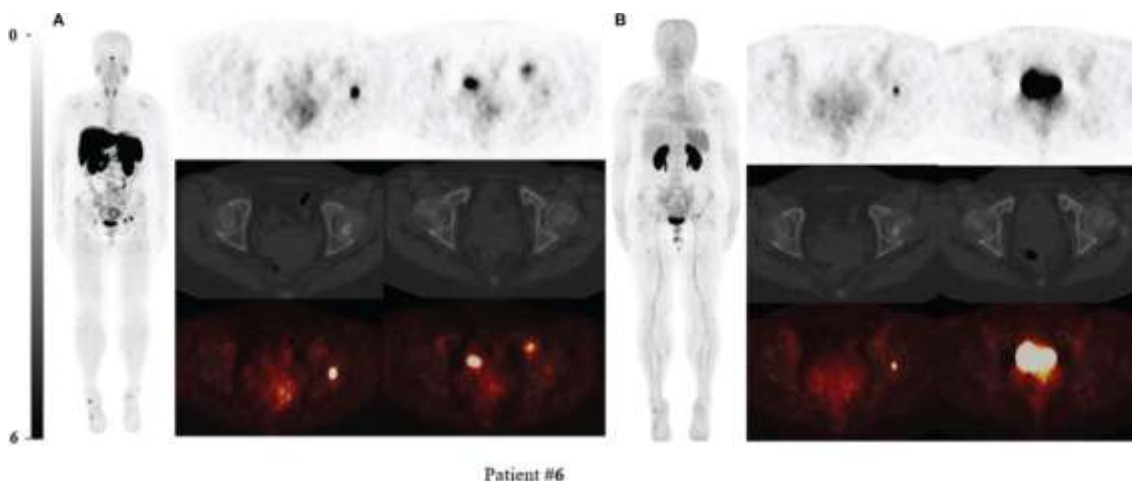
^{68}Ga -DOTA-TATE PET/CT compared with ^{68}Ga -DOTA-JR11 PET/CT in patient with multiple lesions. Two intensive uptake lesions in the left femoral head and left pubic bone revealed a ^{68}Ga -DOTA-TATE PET/CT (A), which suggested that they might be culprit tumours. The lesion of the left femoral head showed osteogenic change. However, the lesion in the left pubic bone only showed slightly increased uptake and the focus in the left femoral head still showed high uptake on ^{68}Ga -DOTA-JR11 PET/CT (B). The lesion of the left femoral head was confirmed as the responsible tumour of tumour-induced osteomalacia by postsurgical pathological results (Hou et al., 2022).
